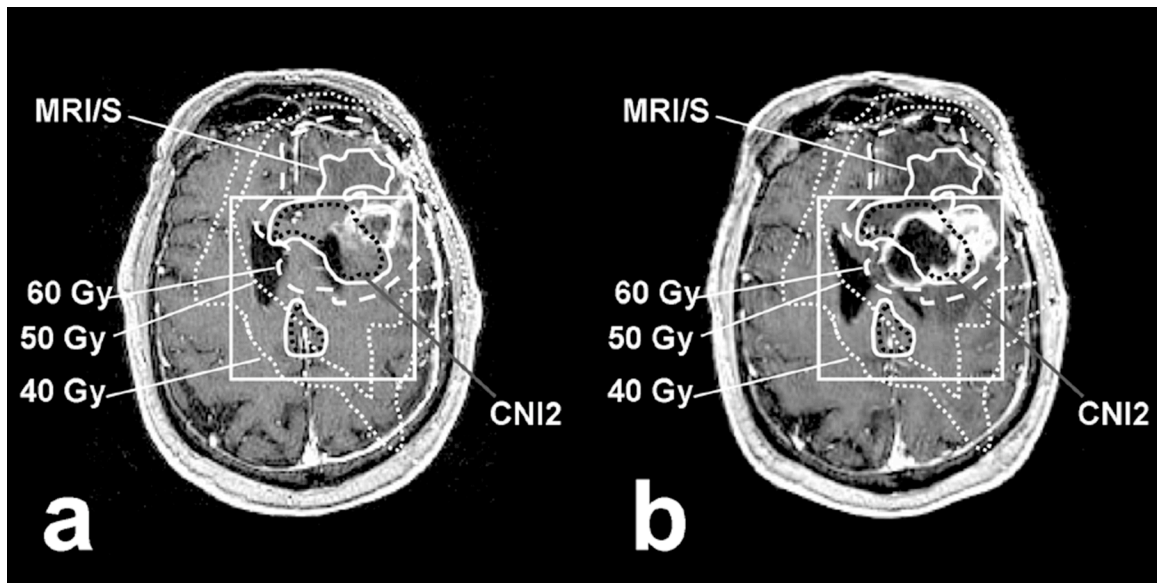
The only patient in whom increased contrast enhancement (CE) occurred beyond the pre-radiation therapy (RT) combined MRI/MRSI was caused by the formation of a large necrotic cyst that caused a significant tissue shift: (a) T1 spoiled gradient echo (SPGR) at Pre-RT. (b) T1 SPGR at 2 months post-RT.
